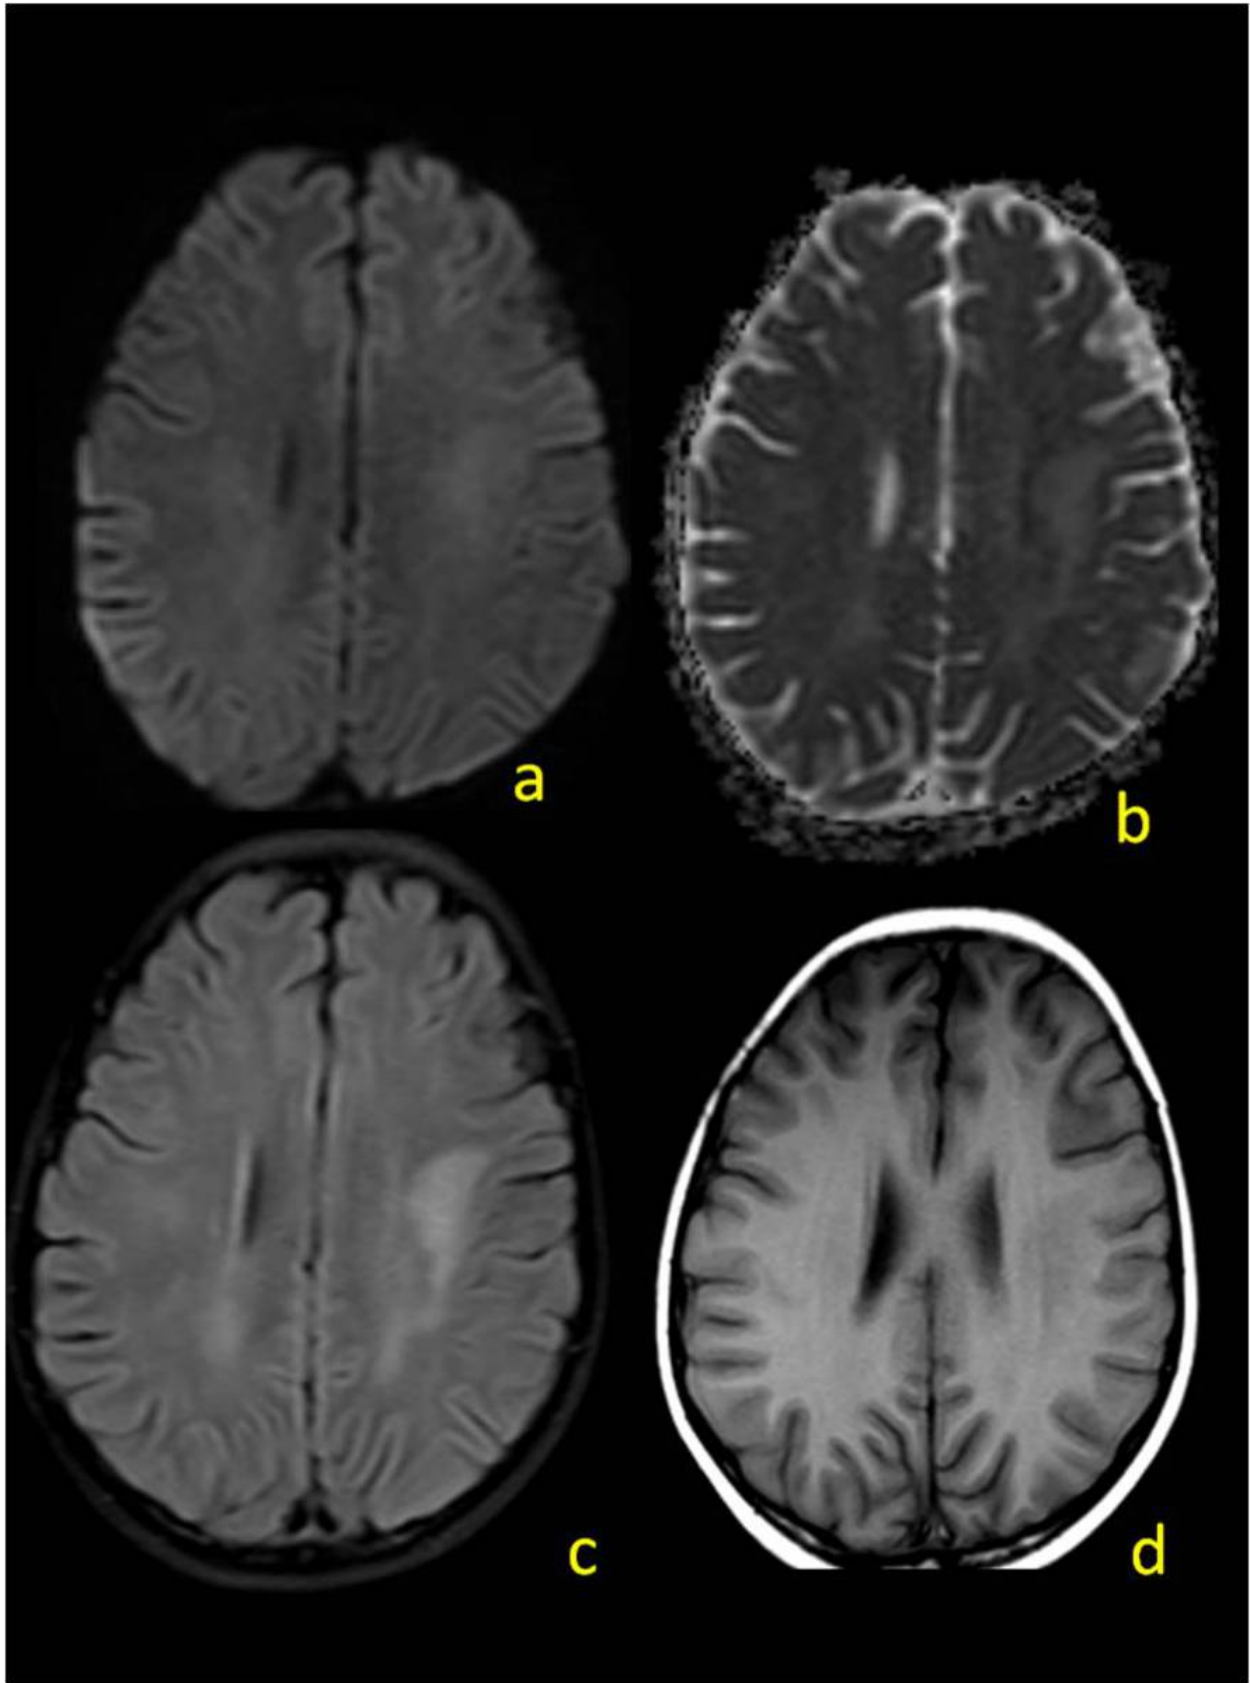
Follow up study for the same patient of (fig. 3) done 10 days later show near total resolution of the restricted diffusion and slight elevation of the ADC value (Fig. a& b) . FLAIR images (Fig. c) show areas of bright signal in the left centrum semiovale, this area is almost isointense on T1WI (Fig. d).
